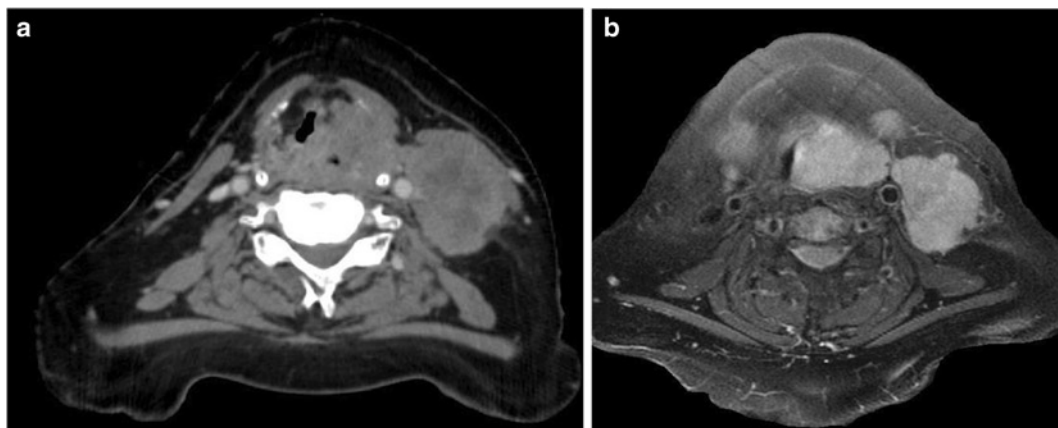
Computed tomography (a) and magnetic resonance (T2-weighted) (b) images of an advanced pyriform sinus cancer invading the thyroid cartilage and directly extending to the soft tissues of the neck (T4a) with large lymph node metastasis (N3)
